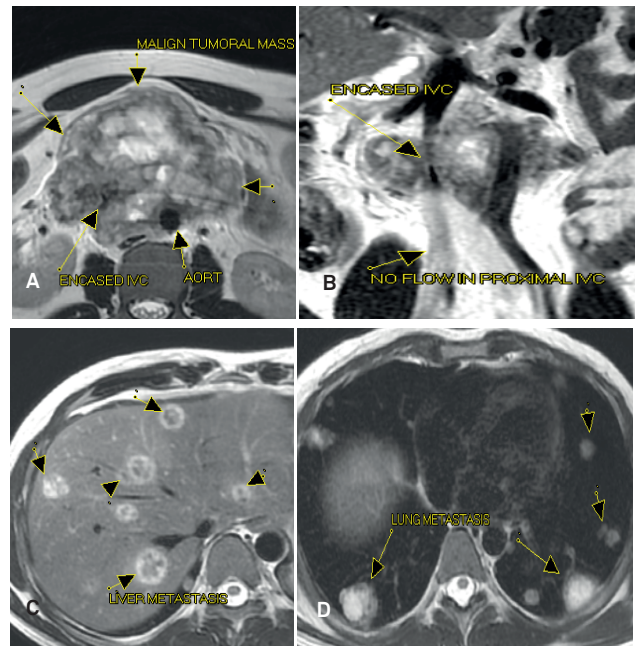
CE MRI of upper abdomen axial plane (a), coronal plane (b): The largest tumor lesion in the central structure includes paraaortic region and lies in order intraperitoneal and retroperitoneal. Heterogeneous lesion. Vases blood infiltration of the aorta and proximal part of the VCI. CE MRI of upper abdomen axial plane (c), liver multifocalis metastases with hepatomegaly and multiple nodular lesions in the lower lobes of the lung—metastatic shared (d).
